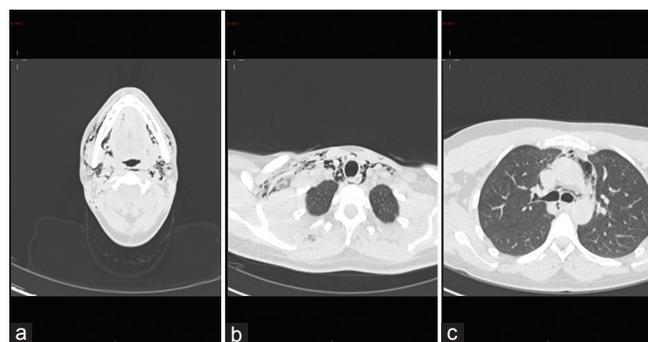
A basal high-resolution multislice computed tomography scan of neck and thorax showed the presence of air bilaterally in sublingual, submandibular, masticatory, and parapharyngeal spaces (a), extended to laterocervical and retroclavicular regions, especially on the right (b), with the evidence of anterior and posterior pneumomediastinum (c)
